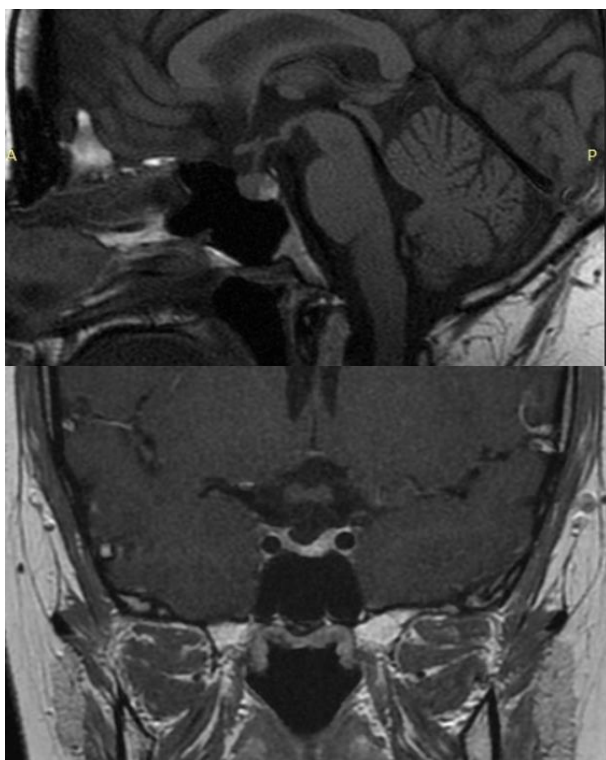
Preoperative IV Contrast MRI performed on a 13-years girl: microadenoma of 5.2mm without suprasellar extension and no mass effect on the pituitary stalk. A: Sagittal plane, B: Coronal plane
